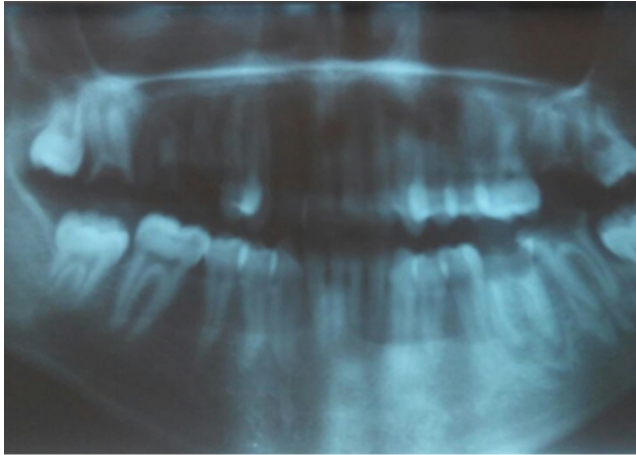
Panoramic radiograph of the dental arch
